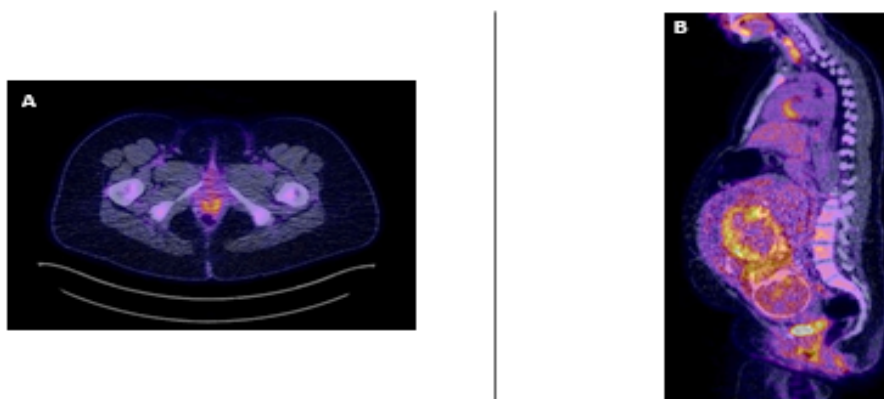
A. Axial PET/CT image. B. Sagittal PET/CT image.
